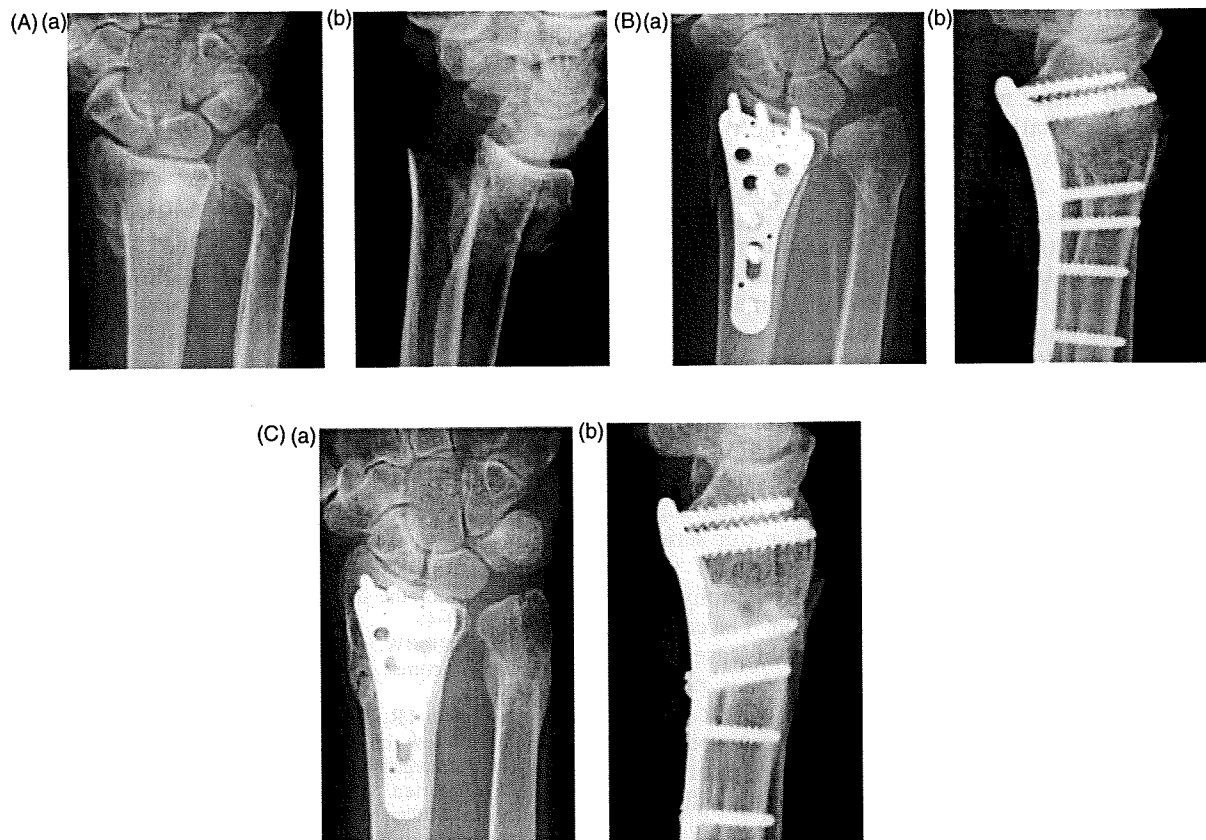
Radiograph of the wrist (case 6). (A) Initial radiograph of the wrist. (B) Radiograph immediately after operation, showing a 14° angulation deformity of the distal ulnar metaphysis (ulnar apex). (C) Final radiograph showing that the angulation apparent at the immediate postoperative stage had disappeared by final follow-up. All radiographs show (a) anteroposterior and (b) lateral view.
